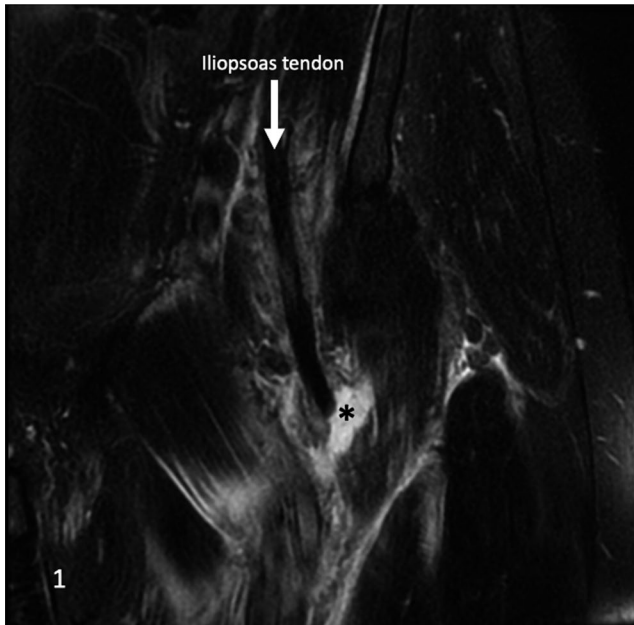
Coronal T2 MR image of the left hip with fat saturation demonstrating the iliopsoas tendon with the torn aspect surrounded by edema (*)
